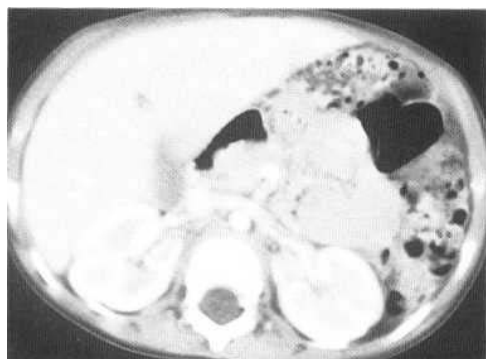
Computed tomography. Axial image through renal hilum shows clearly the left renal vein and right renal artery. There is prominent fetal lobulation and corticomedullary differentiation.
